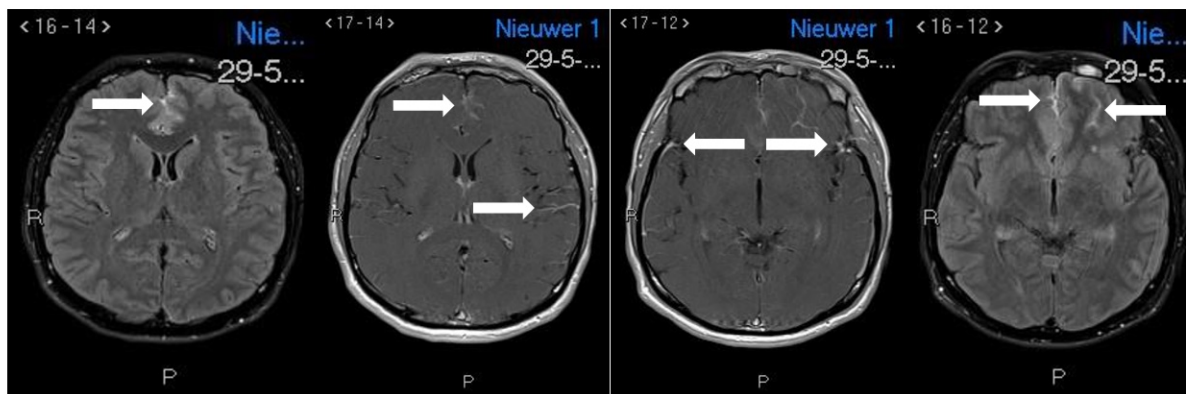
Axial T1- and T2-weighted-Fluid-Attenuated Inversion Recovery show multifocal leptomeningeal enhancement mostly at the left frontal lobe and centrally in the cerebellum.
